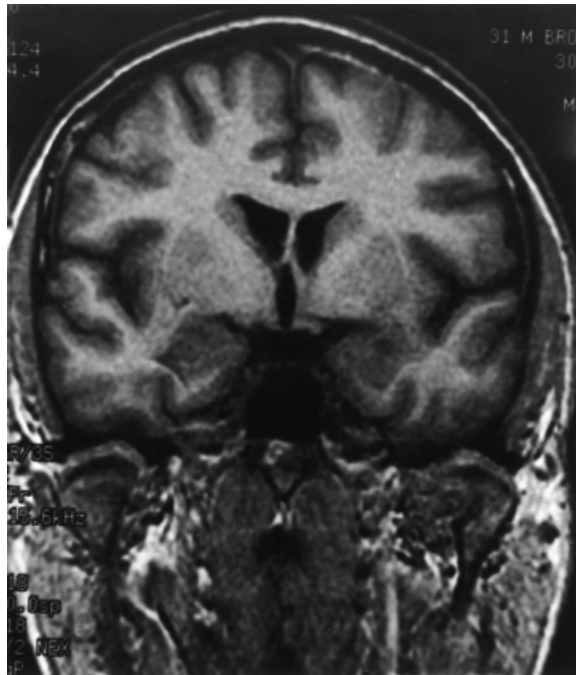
MRI scan showing abnormal signal return on T₂ and possible low-intensity lesion in T₁ in the lateral part of the basal nuclei of the left amygdala.
